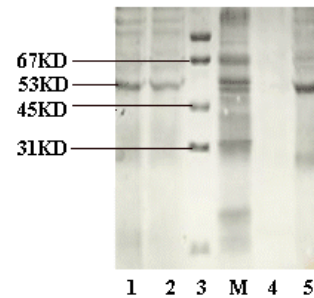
SDS-PAGE of recombinant protein after purify. M: Marker; Lane 1: HIV Tat-TK; Lane 2: HIV Tat-(Gly)₂-TK; Lane 3: mixture protein of *E. coli* after ultrasonic destroy; Lane 4: HIV Tat-(Gly)₄-TK; Lane 5: HIV Tat-(Gly)₆-TK.
